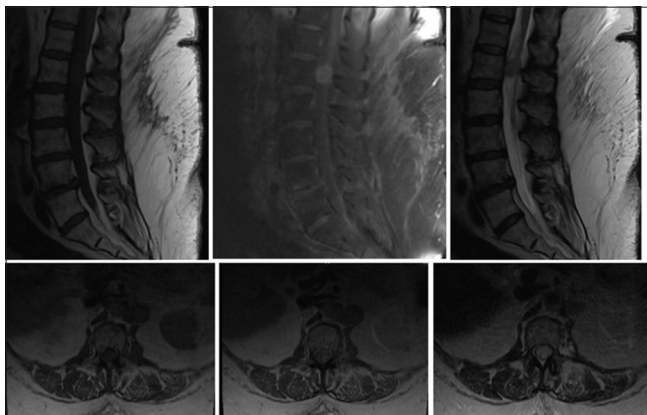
Preoperative magnetic resonance imaging of the lumbar spine shows the intradural spinal cord lesion. Top row, from left to right: sagittal T1 without contrast, sagittal T1 with contrast, sagittal T2. Bottom row, from left to right: axial T1 without contrast, axial T1 with contrast, axial T2.
